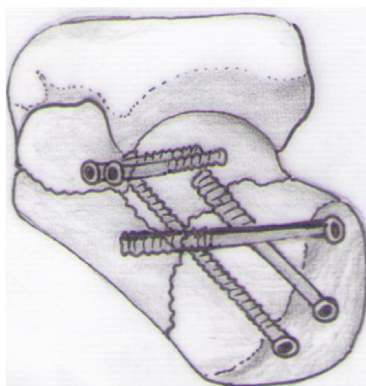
(a) Placement of the screw (b) post op x-ray.
